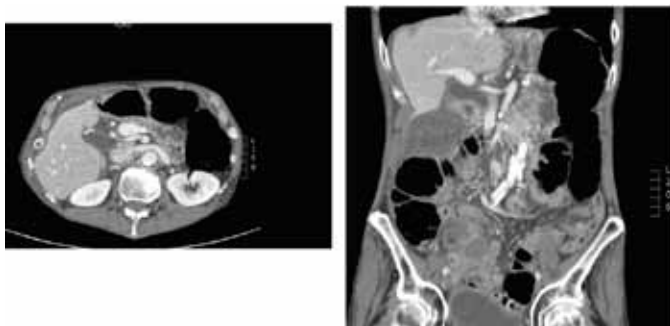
Abdomen computed tomography with intravenous contrast: a fluid filled, not well-defined structure noted inferior to the liver with small amount of fluid adjacent to the liver, likely dilated gallbladder.
